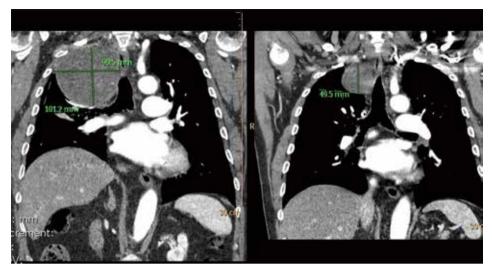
Computed tomography (CT) shows enlargement of cystic lymphangioma during a periode of 5 years (cystic value 10-20 on Hounsfield scale).
